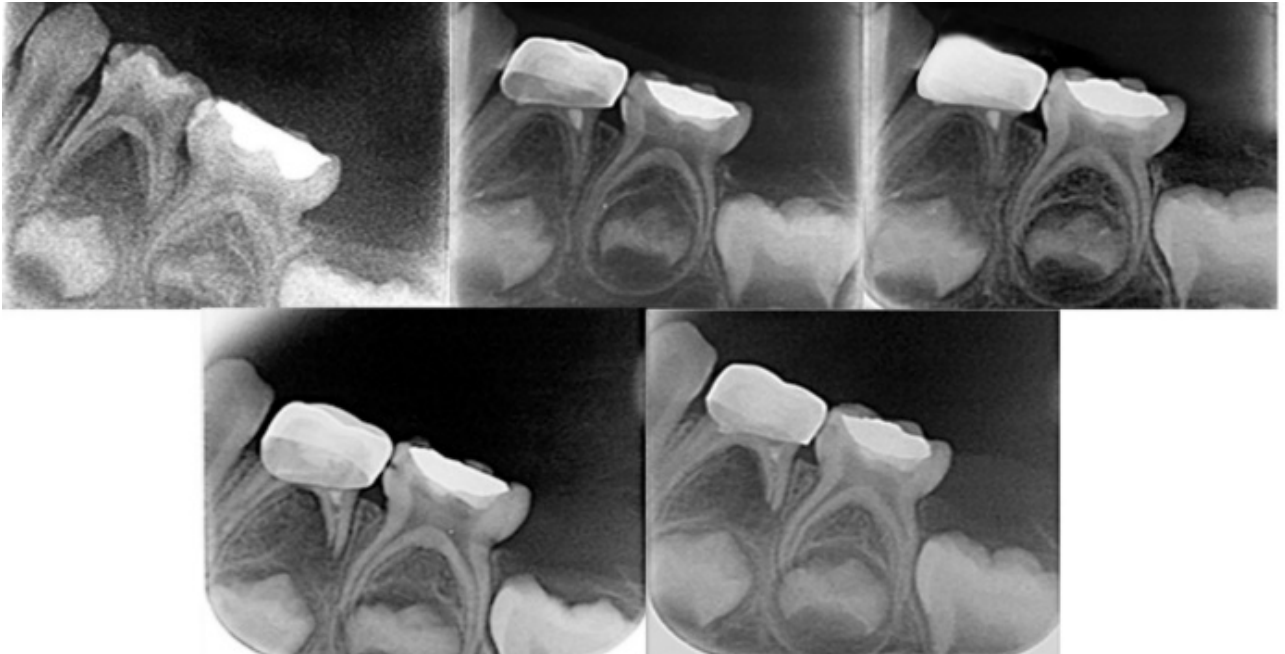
A: pre-operative radiograph showing proximal mesial caries to lower right D, B: base line image immediately after restoration with 3trimix and (C-D): follow up periods at 3, 9 and 12 months post restoration respectively.
